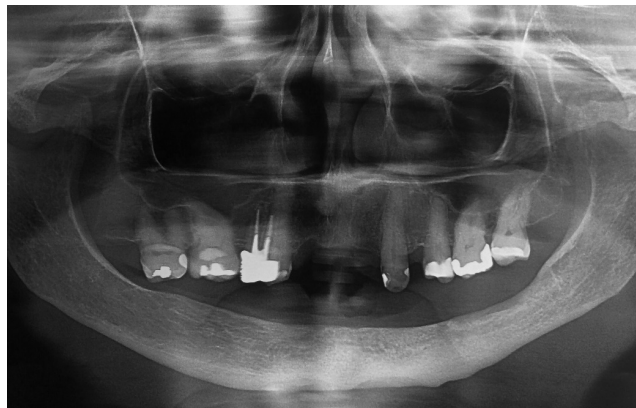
Panoramic radiography at 16 months postoperative
